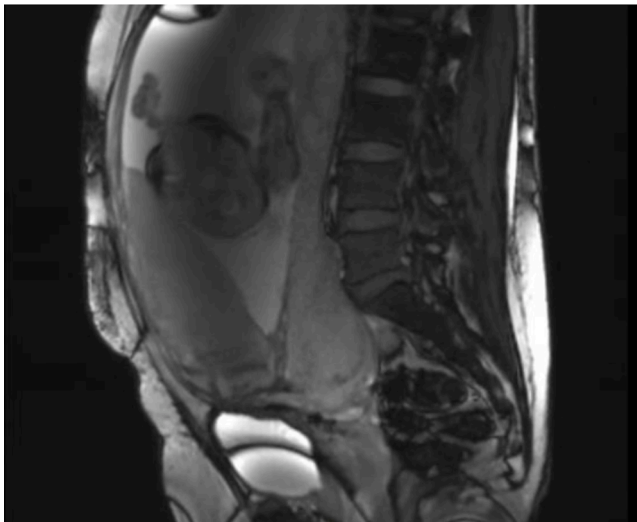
Repeat non-contrast MRI abdomen/pelvis at 28 week's gestation. Unchanged focal lobulation of the placenta filling the lower uterine segment. Increase in low signal tissue/fibrosis within the left aspect of the placenta anterior to the focal placental/uterine bulge with absent interface between this placental tissue and the wall of the left bladder dome.
